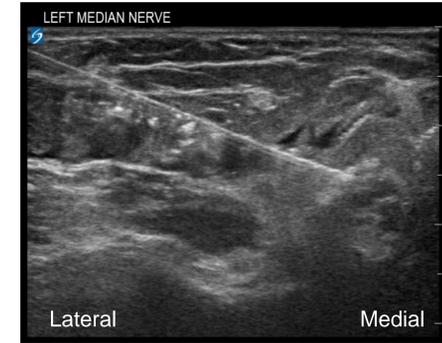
Ultrasound guided hydrodissection of the left transpositioned median nerve.
